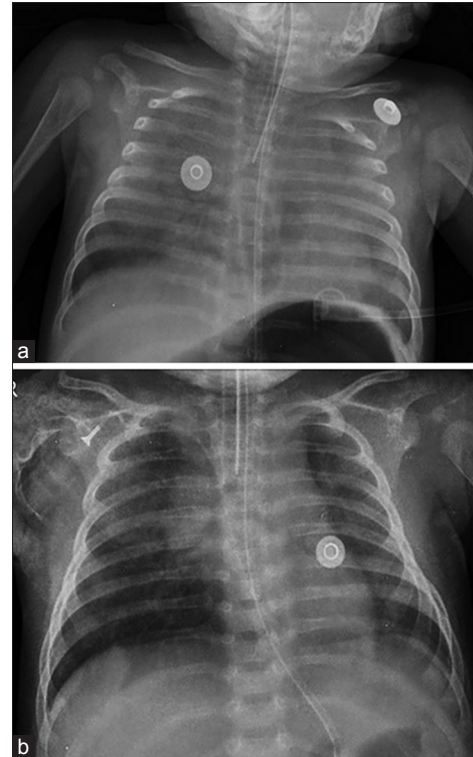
(a) Diffuse air space opacities in both lung fields (b) Repeat X-ray showing marked clearing of infiltrates
